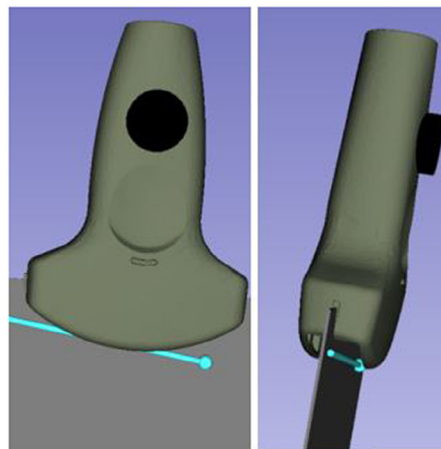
Result of the calibration of the ultrasound (US) image plane with respect to the US probe location brought by the electromagnetic (EM) tracking system.
